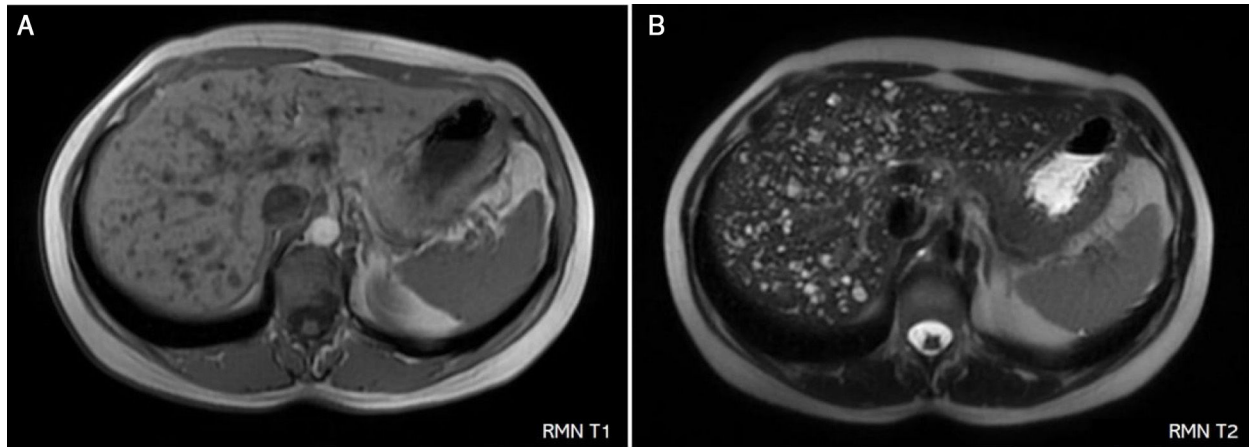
Abdominal magnetic resonance imaging: Numerous round lesions, hypointense on T1 (2a) and hyperintense on T2 (2b).
